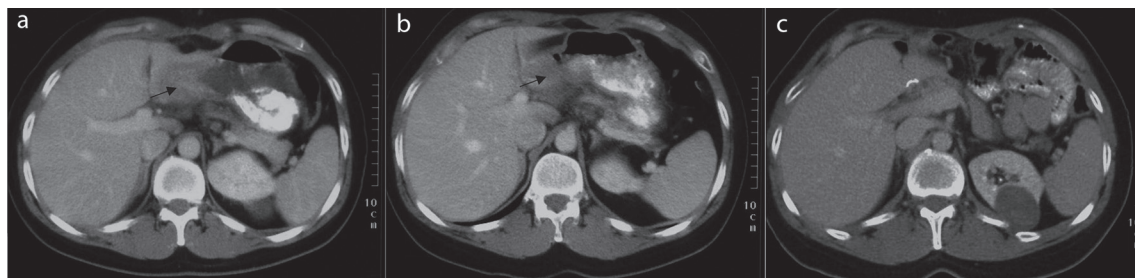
Abdominal CT scans. a) before treatment December 2003 b) after partial remission May 2004 c) after complete remission November 2005.
